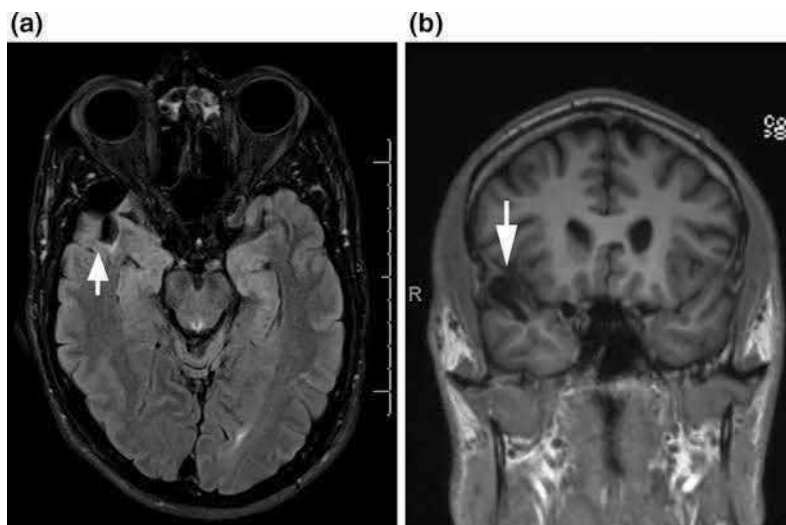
Axial FLAIR (a) and coronal 3D T1-weighted MRI (b) demonstrating subtle encephalomalacia in the anterior right superior temporal gyrus (arrows) attributed to remote trauma in a patient with seizures and history of high-speed motor vehicle accident.
